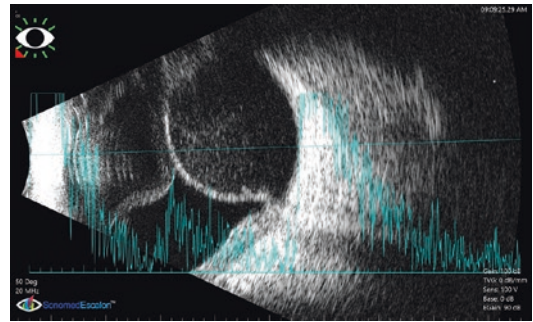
Combined A- and B-scan ultrasonography of hemorrhagic choroidal detachment. B-scan revealed markedly elevated dome-shaped appearance with fine amorphous echoes in the suprachoroidal space “moderate hemorrhage.” A-scan revealed a 100% high double spike (retina and choroid)
